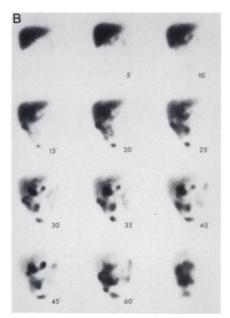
(A) Hepatobiliary scintigraphy performed on a 4-mo-old infant (Patient 2 in Table 1) with obstructive jaundice shows no activity in the gallbladder or in the intestine resembling the pattern seen in biliary atresia. (B) After 3 mo of medical therapy with ursodeoxycholic acid, a follow-up hepatobiliary scintigraphy shows normal flow of bile into the gallbladder and intestine. (C) Ultrasound shows inspissated bile in the gallbladder of Patient 2 (corresponds to A).
